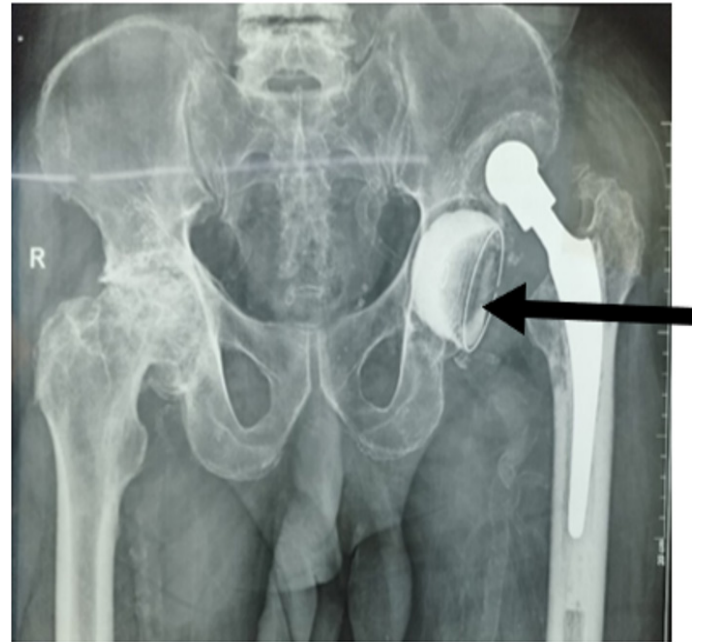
Radiograph of a patient showing loss of permanent relationship between the prosthetic head and the acetabulum, indicating prosthetic dislocation.
